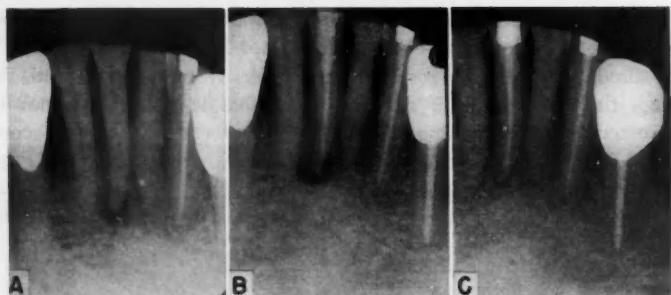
Lower incisor in 66 year old patient showing periapical bone involvement. Patient presented with symptoms of an acute dento-alveolar abscess. A, Before treatment; B, immediately after treatment; C, 2½ years after treatment.
